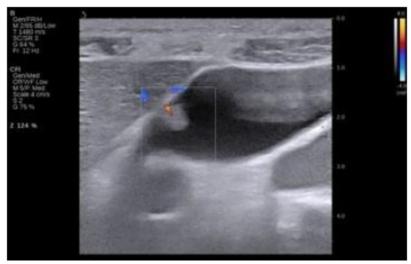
Polyp with vascular pedicle present in Doppler US examination.
